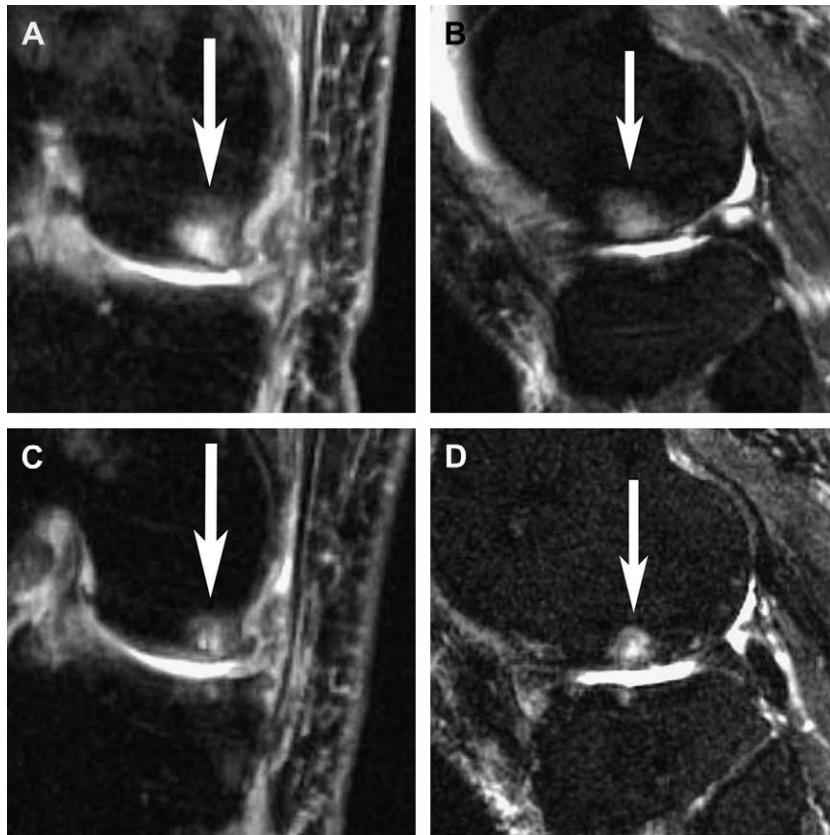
Fifty-three-year-old male with subchondral cyst development. Baseline MRI: T2-weighted coronal (A) and sagittal (B) images show a subchondral region of bone marrow edema-like signal in the central portion of the lateral femoral condyle (arrows). Follow-up MRI 12.5 months later: T2-weighted coronal (C) and sagittal (D) images now show a subchondral region of well-circumscribed high signal intensity in the central portion of the lateral femoral condyle arising in the pre-existing bone marrow edema-like signal lesion (arrows). Note that the lateral meniscus body is absent reflecting a displaced tear.
